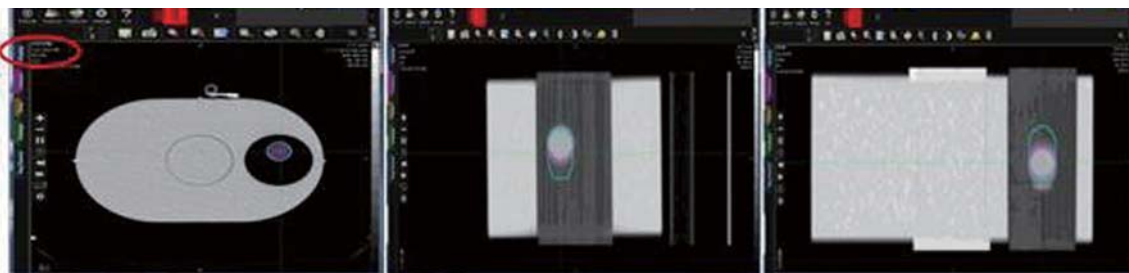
A typical series of CT images in transverse, sagittal, coronal view by phase-binning algorithm
